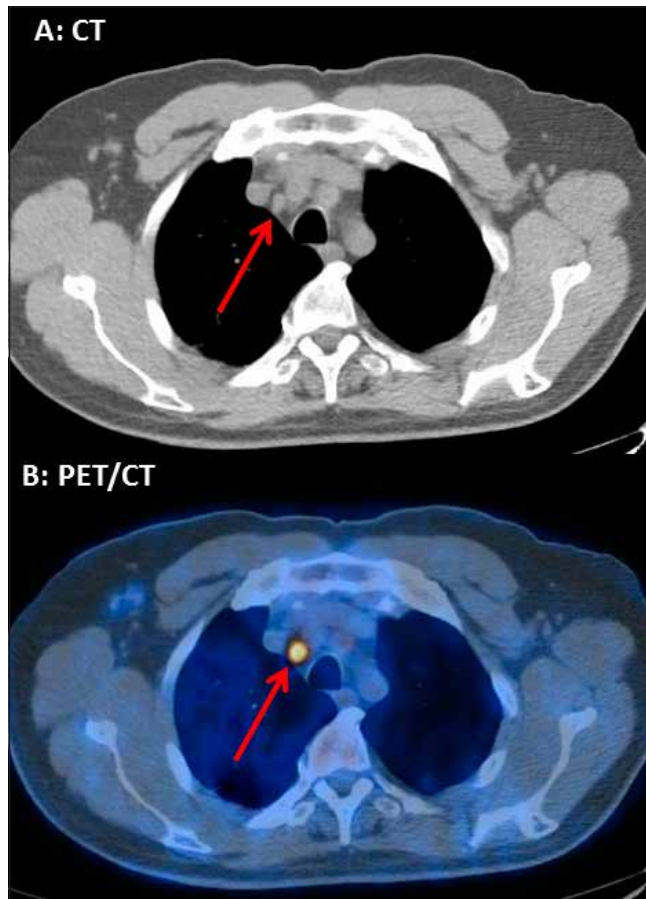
An axial slice on A: CT and on B: fused PET/CT of a patient with true positive upper right paratracheal lymph node at surgery. The red arrows denote the position of the node which is of borderline significance on CT size criteria alone but is clearly FDG avid positive on PET/CT.
